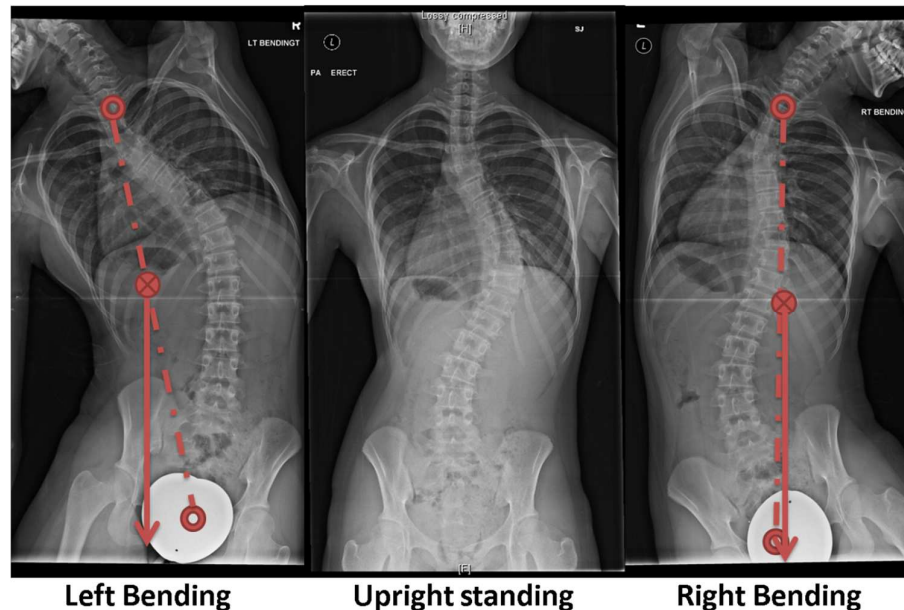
X-ray images of the scoliosis female subject in bending right and left postures
